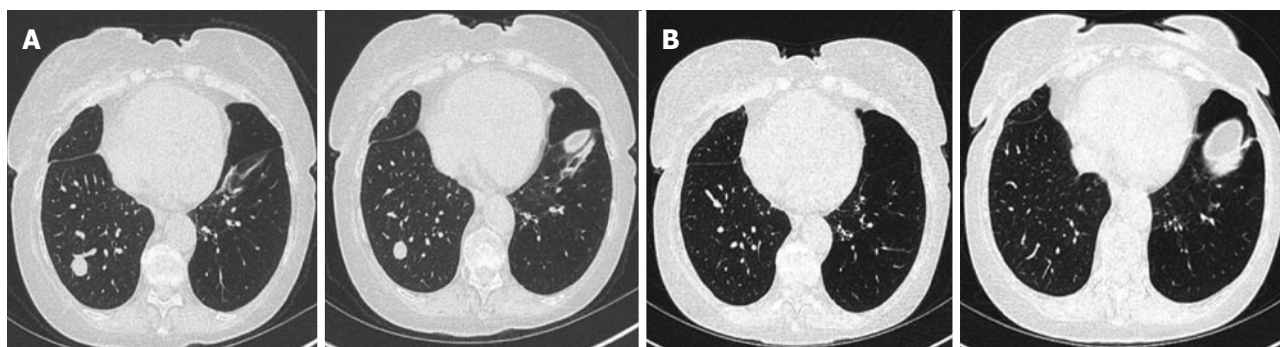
Computed tomography of chest. A: Day 40. Note a well circumscribed, round pulmonary nodule involving the right lower lobe. Transbronchial biopsy was obtained from this site 40 d earlier; B: Day 90. Note the total resolution of the right lower lobe nodule.
